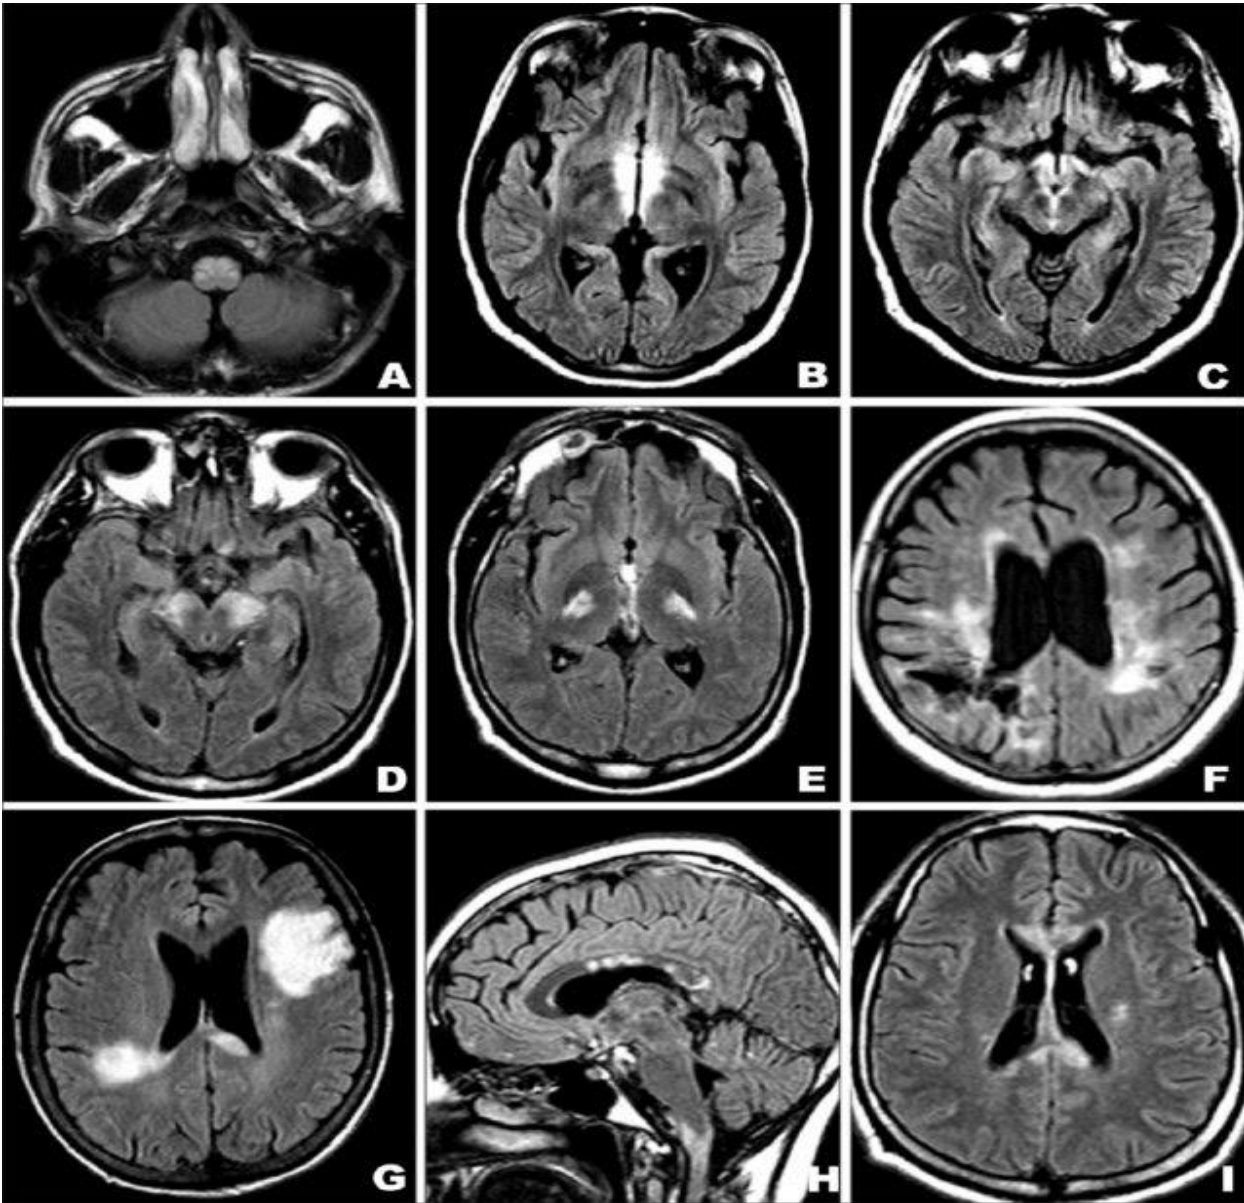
Brain lesion distribution in our patients with Neuromyelitis Optica. MRI FLAIR images. (A) medulla involvement. (B, C) lesions in diencephalon and optic chiasm. (D, E) signal abnormalities in middle cerebellar peduncles, midbrain and internal capsule. (F) white matter abnormalities with cavitations suggesting early axonal loss. (G) lesions in the periventricular and subcortical cerebral white matter and corpus callosum. (H) corpus callosum, optic chiasm and medulla involvement. (I) corpus callosum lesions and slight signal abnormalities in periventricular cerebral white matter. Adapted from [88](#).
